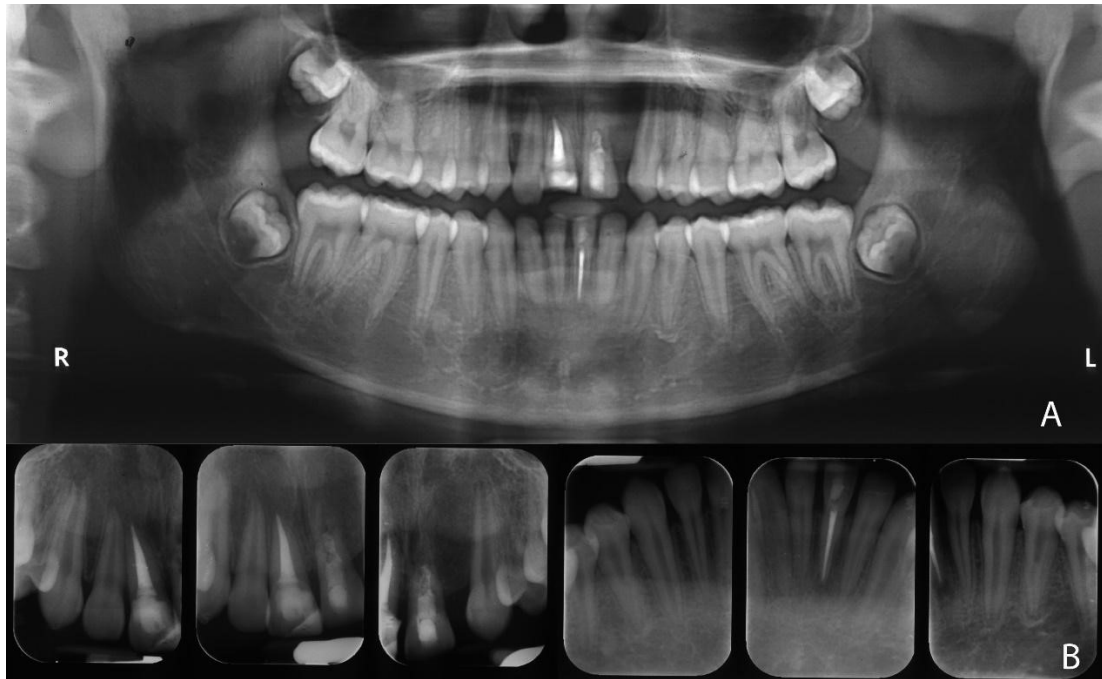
A pretreatment panoramic radiograph, B pretreatment periapical radiograph of maxillary and mandibular anterior teeth
